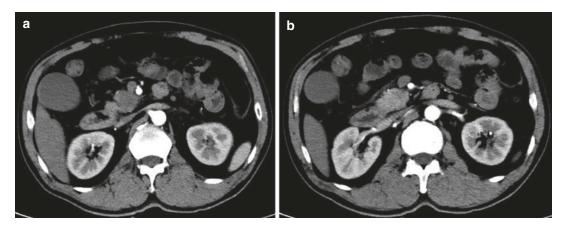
(a, b) CT image showed a mass in the ampullar region
